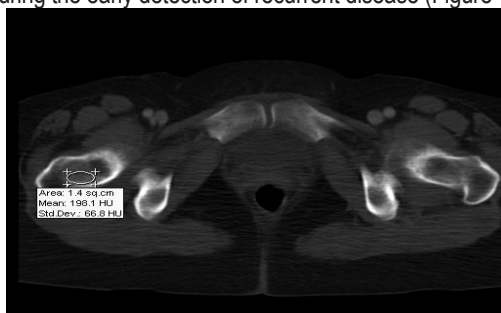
Comparison of conventional CT and PET scans of the same patient. The FDG uptake in the PET image can easily indicate a possible recurrent disease.
